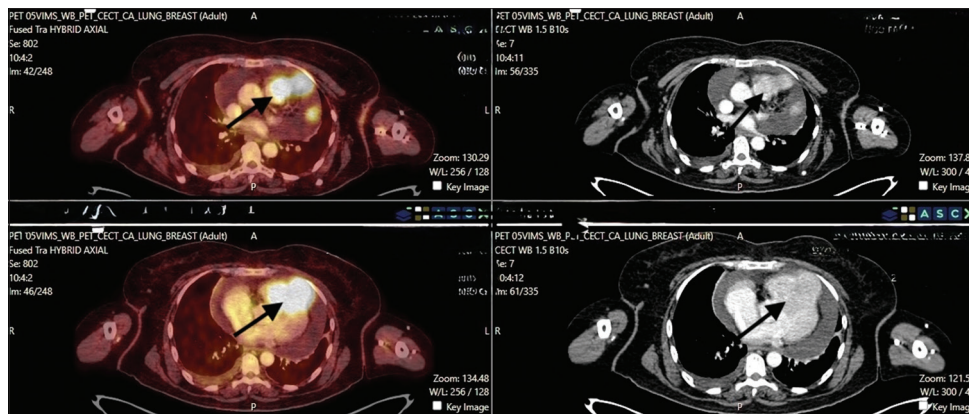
Positron emission tomography-computed tomography showing fluorodeoxyglucose avid heterodense mass (pointed by arrow) involving the right ventricle wall, interventricular septum, and left ventricle myocardium extending into the pulmonary trunk
